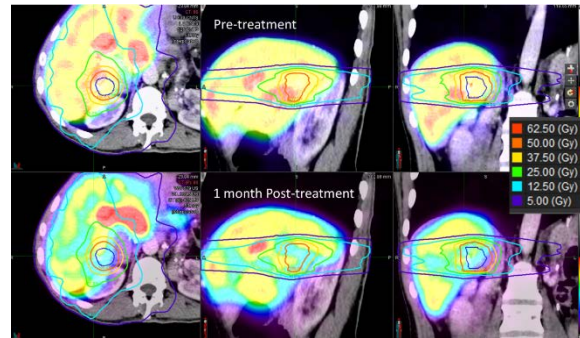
Pre (top) and post-treatment 99m-Tc Mebrofenin SPECT images overlaid on the treatment planning CT scan. Isodose lines from a 50 Gy in 5 fx treatment are shown. SPECT colourmaps are normalized to the counts in liver receiving < 5 Gy.
